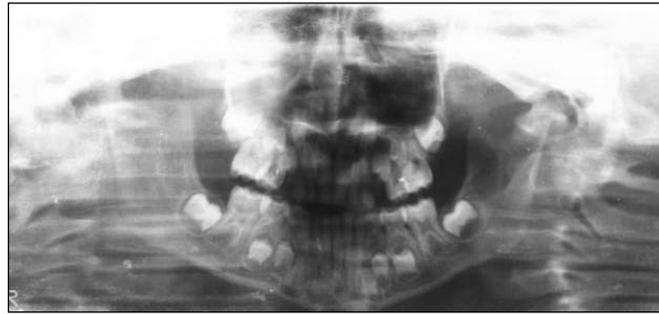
Case 1: Orthopantomogram, 9 years 4 months
